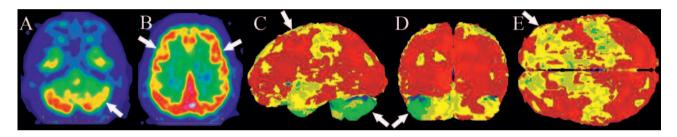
Brain FDG-PET (A and B are axial images; C, D, and E are 3D reconstruction images with respectively lateral view, posterior view, and superior view) showing profound left predominant cerebellar hypometabolism (A, C, D) and moderate frontal hypometabolism (B, C, E).
